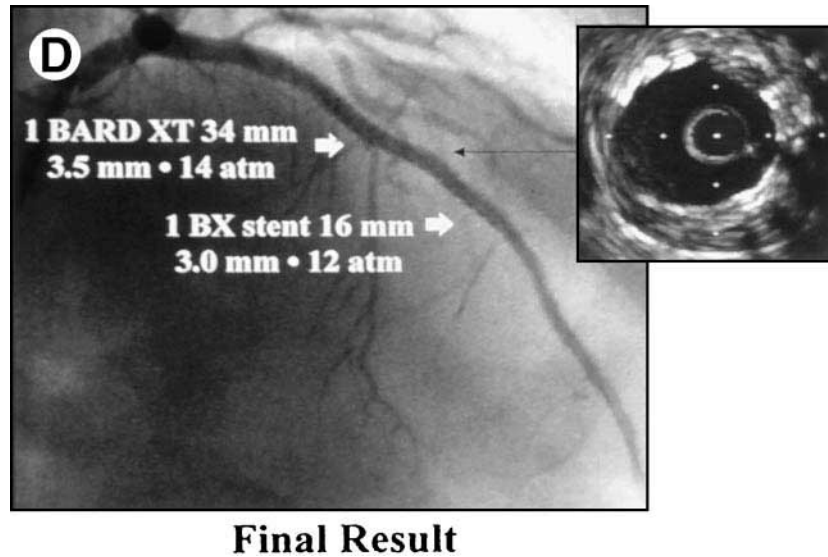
Treatment of diffuse disease in the mid and distal LAD was attempted with balloon dilatation alone (A). However, dilatation with a 40-mm long balloon resulted in a type C dissection (B). Although the lumen did not appear compromised by angiography, by ultrasound examination this dissection extended further than appreciated, and the disrupted plaque compromised the lumen (C).
